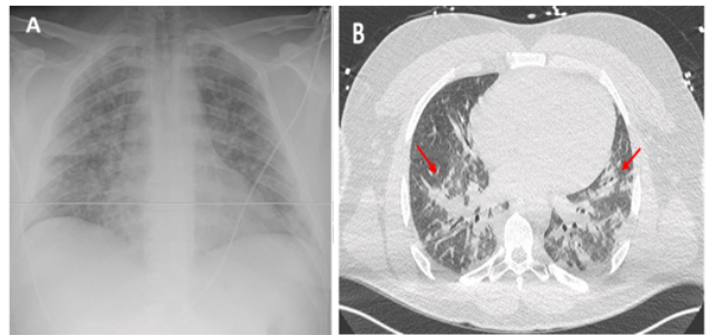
Chest radiography (A) and CT-Scan showing multiple bilateral infiltrates extending to all 2 lung fields (red arrow).
